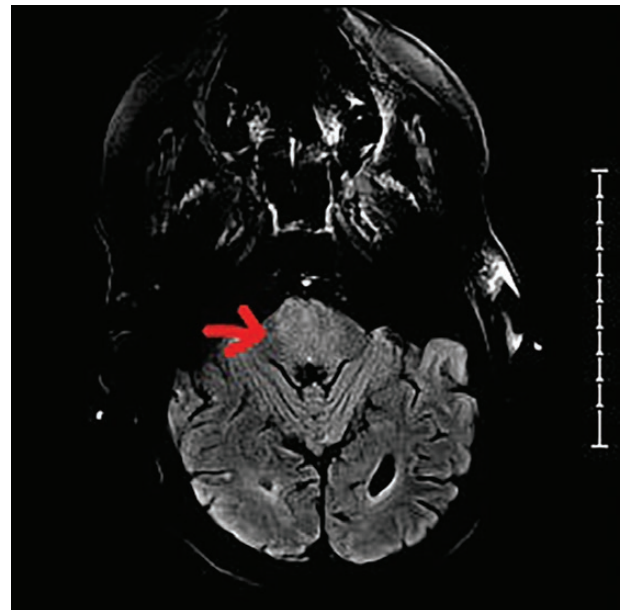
Patient 2 MRI with mild diffuse FLAIR hyperintensity in the periventricular white matter and brainstem. Abbreviations: FLAIR, ; MRI, magnetic resonance imaging.
